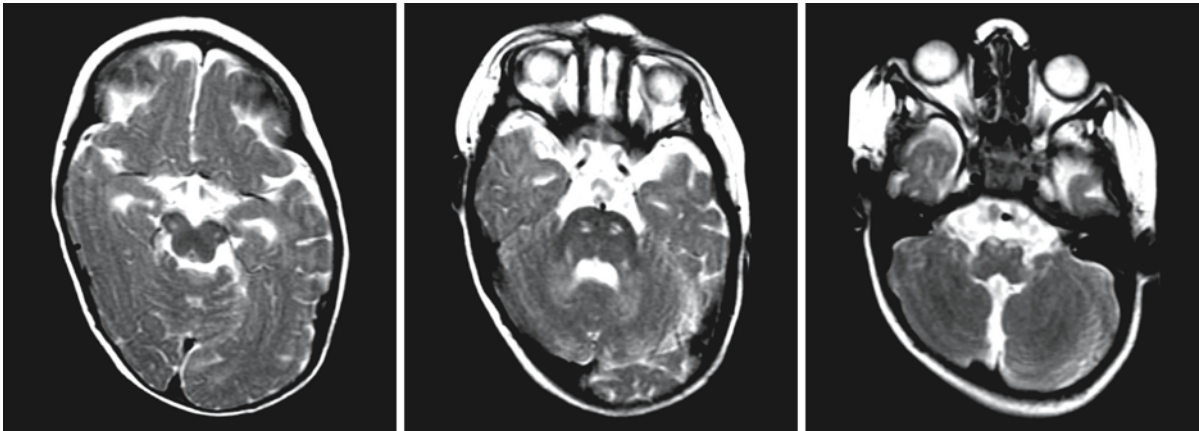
Follow-up MRI of the same boy with BPD at the age of 22 months. Demyelination has started in the pyramidal tracts of the brain stem. The cerebellar white matter is also
